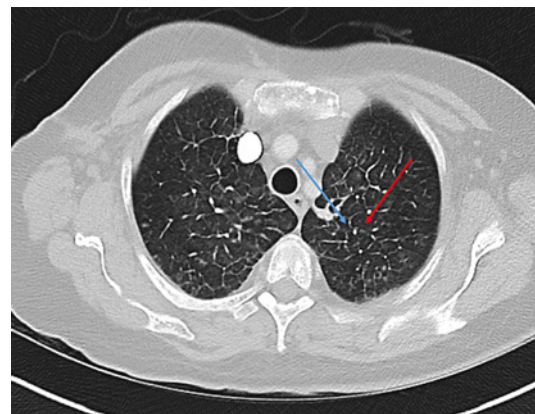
CT scan of the chest demonstrating (blue) thickened interlobular septa, (red) centrilobular faint compression.
